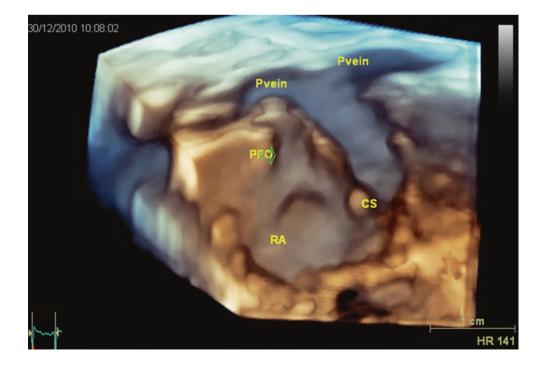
Echocardiographic image: total anomalous pulmonary venous drainage to coronary sinus, 3D. *Pvein* pulmonary vein, *PFO* patent foramen ovale, *RA* right atrium, *CS* coronary sinus
